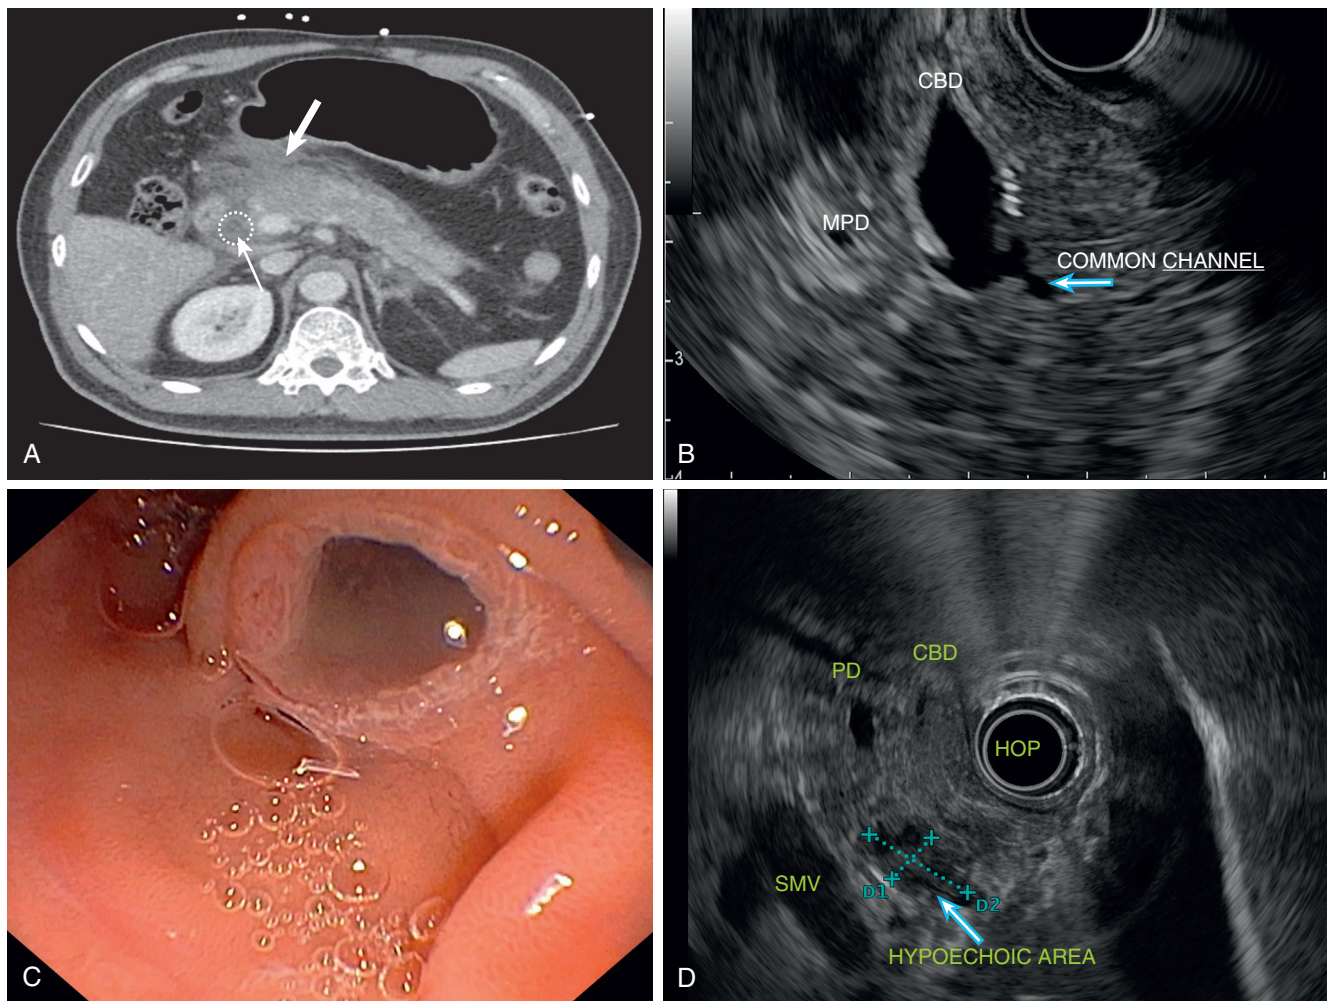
Causes of acute pancreatitis. A, Cross-sectional computed tomography (CT) image of acute biliary pancreatitis. Thin arrow, Small gallstones within common bile duct (circle); thick arrow, edematous head and neck of pancreas with peripancreatic fluid. B, Anomalous pancreaticobiliary duct junction (ABPJ) on endoscopic ultrasound (EUS). Arrow, Common channel; CBD, common bile duct; MPD, main pancreatic duct. C, Endoscopy picture of fish-mouth papilla with mucus coming out, main duct. Intraductal papillary mucinous neoplasm causing pancreatitis. D, Initially diagnosed idiopathic pancreatitis. Cross-sectional imaging (e.g., CT) did not detect a cause of lesion, but further workup with EUS reveals the lesion as a hypoechoic area (arrow), which proved to be a pancreatic adenocarcinoma. HOP, head of pancreas; PD, pancreatic duct; SMV, superior mesenteric vein. (Images courtesy Dr. Damien Tan and Dr. Ser Yee Lee.)
